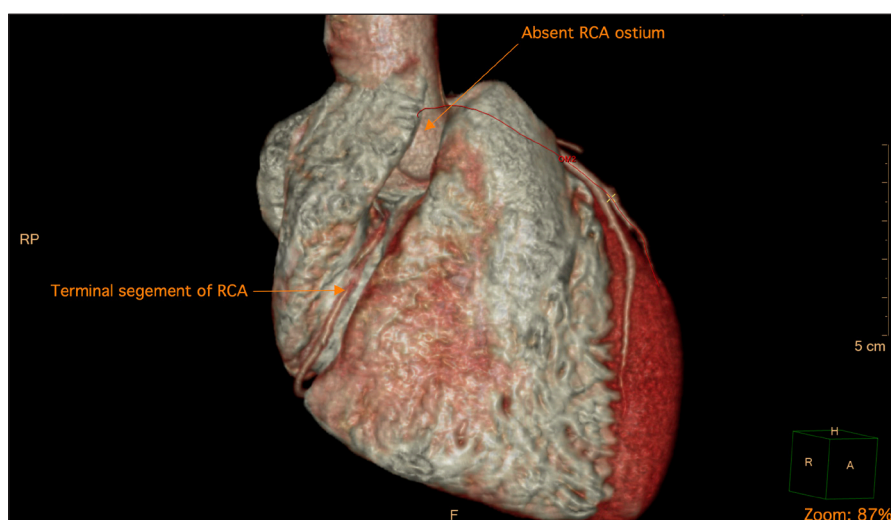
Cardiac computed tomography angiography 3-dimensional reconstruction showing absent right coronary artery (RCA) ostium and terminal segment of RCA.
